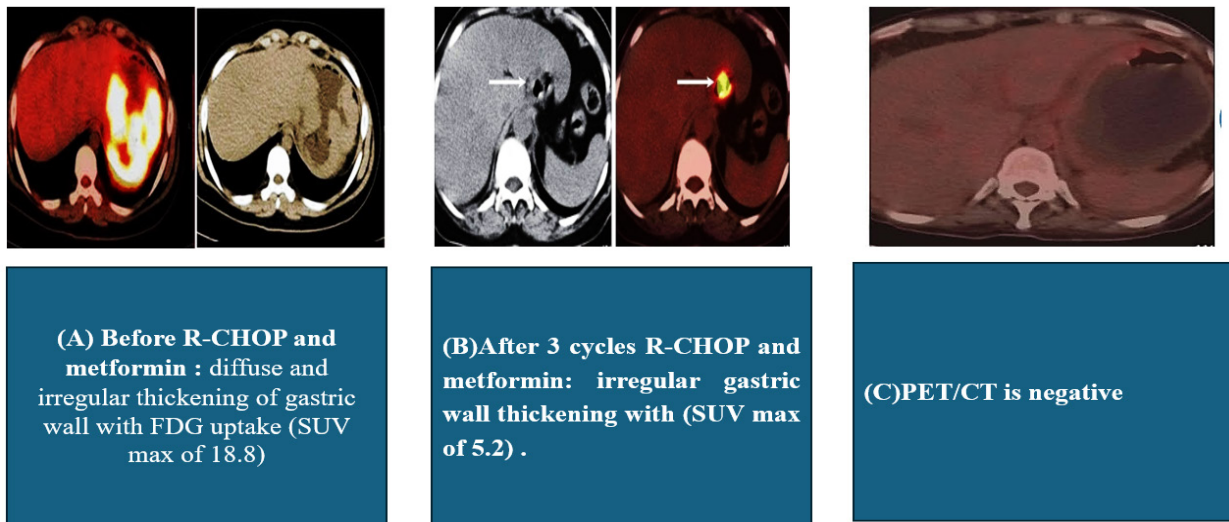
PET/CT Images of Gastric Lymphoma before, after 3 Cycles and 6 Cycles of R-CHOP
